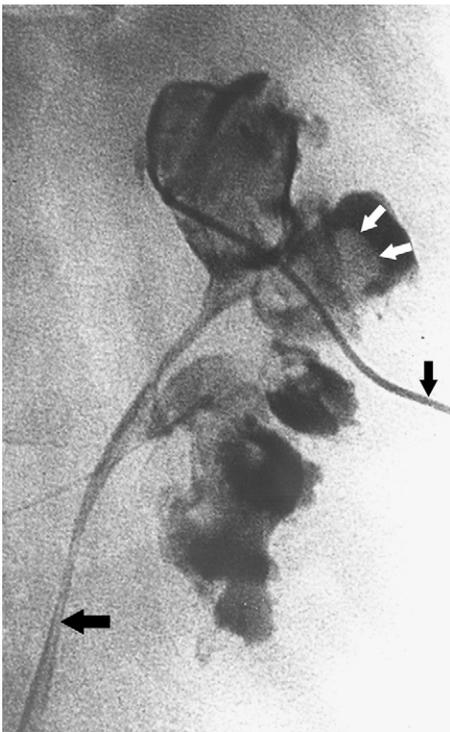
Drainage of hydronephrosis due to *Torulopsis*. In this patient with hydronephrosis on sonography (not shown), a percutaneous nephrostomy tube and ureteral stent were placed (arrows). Note filling defects (white arrows) in the dilated calyces due to debris and fungal elements.
